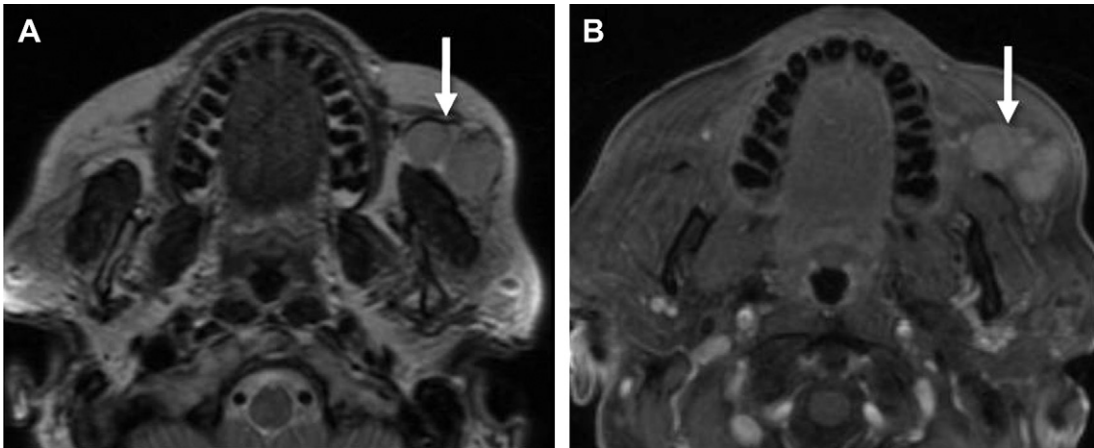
Benign mixed tumor arising in accessory parotid tissue. (A) Axial T2-weighted image shows T2 hyperintensity (arrow) in this BMT. (B) Axial postcontrast fat-saturated T1-weighted image shows well-defined lobulated enhancing mass (arrow) in accessory parotid tissue superficial to the left masseter muscle.
